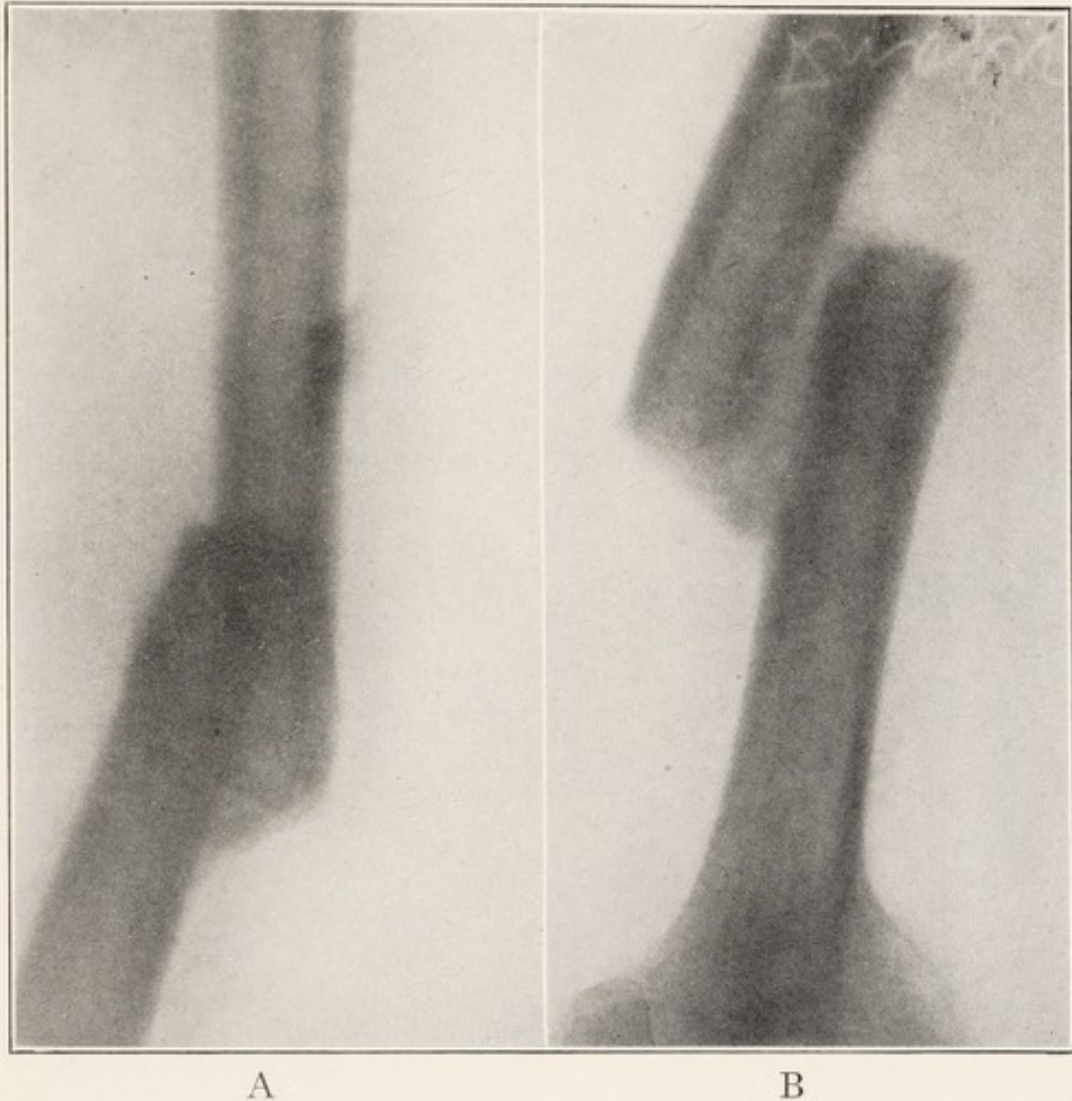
X-RAY SHOWING MAL-UNITED FRACTURE OF SHAFT OF FEMUR, ANTEROPOSTERIOR VIEW.
